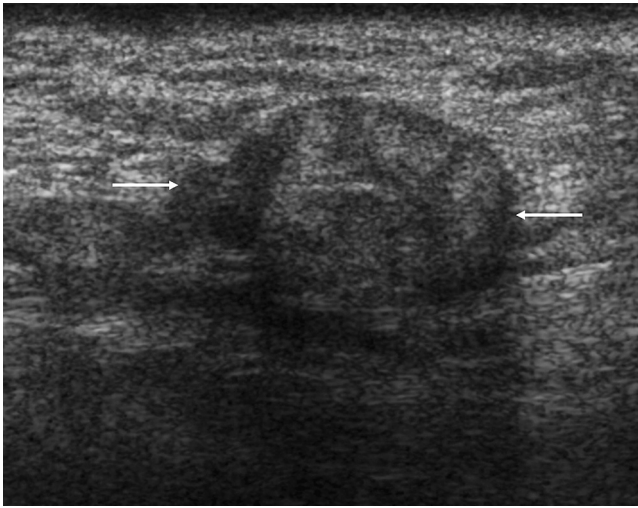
A scar granuloma. The patient had a history of a laparotomy for complicated cholecystitis and presented with an abdominal wall mass 6 months after the surgery. Transverse sonography, showing a well-defined hypoechoic lesion (arrows) with acoustic shadowing at the surgical scar suggestive of scar granuloma and confirmed with clinical follow-up, which showed no serial change in 5 years.
